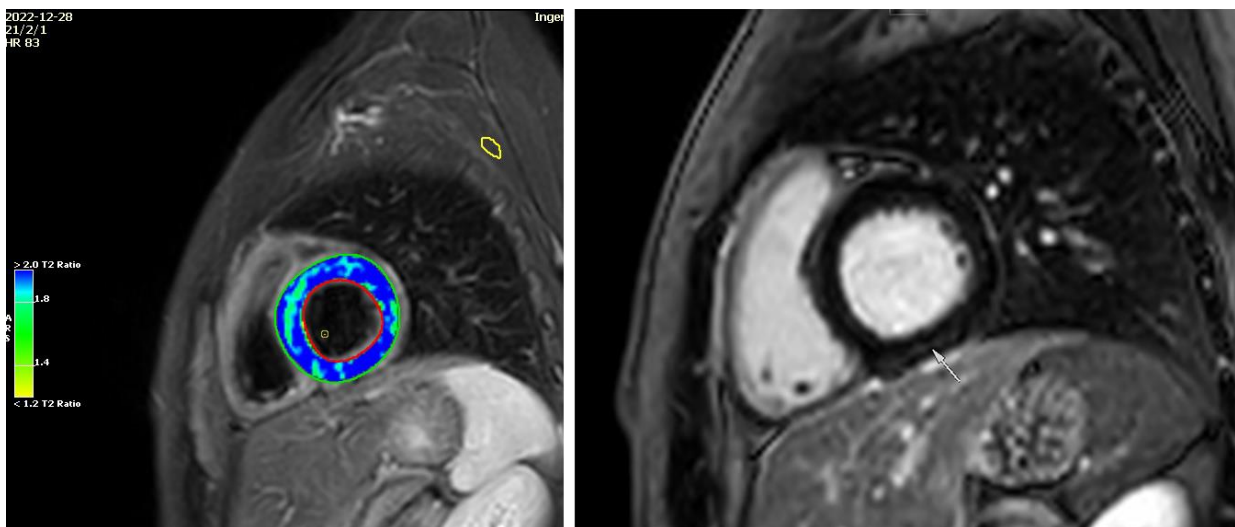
The images showcase short-axis views from cardiac magnetic resonance imaging. Left: Spin echocardiography with triple inversion recovery (STIR) images reveal diffuse myocardial edematous changes with a signal intensity ratio >2.1 compared with the skeletal muscle. Right: Late gadolinium enhancement images show faint subepicardial enhancement in the inferior basal midsegments.
